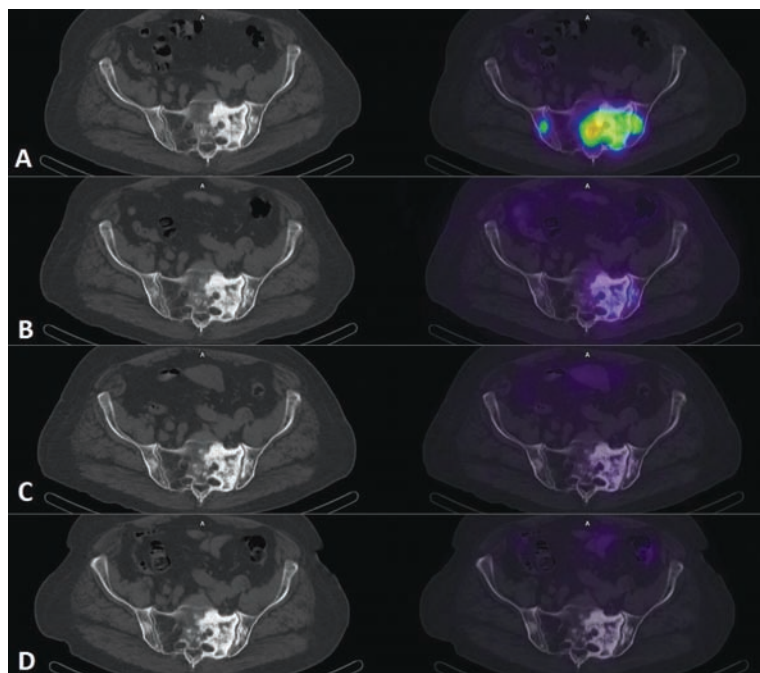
Imágenes SPECT/CT de paciente con cáncer de próstata avanzado bajo tratamiento con ^{177}Lu -PSMA-617. En columna izquierda CT con lesión osteoblástica en sacro y hueso iliaco derecho y en columna derecha imagen fusión SPECT/CT realizadas 24 hrs. post 1ª dosis (A), 2ª dosis (B), 3ª dosis (C) y 4ª dosis (D) respectivamente, con progresiva menor captación del radiofármaco, sugerente de respuesta a terapia.
